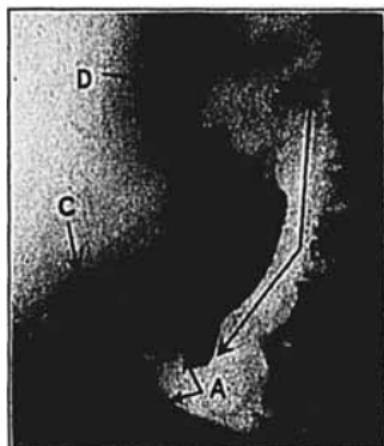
Lateral roentgenogram of retained bismuth meal in the esophagus, the cardiac end of which is stenosed by cancer of the nodular, cauliflower type. *A*, zone of cancer, irregularly canalized; *B*, dilated and partly filled esophagus; *C*, heart shadow; *D*, shadow of aortic arch; *E*, dilated, but not filled, esophagus, the dilatation extending above the tracheal bifurcation. (Roentgenogram by Joseph Johnson.)
